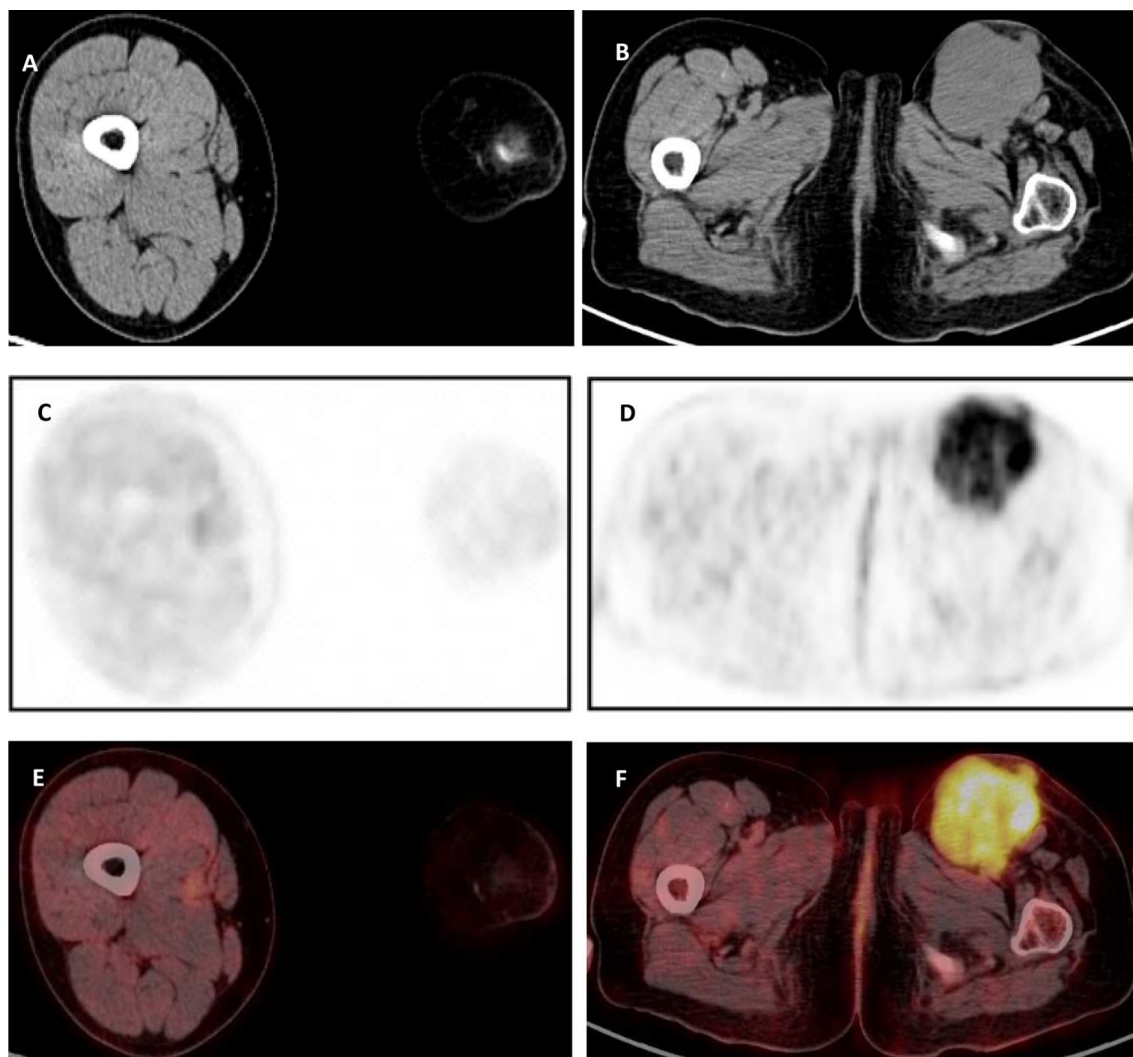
A 33 years old female patient with biopsy-proven left tibial Ewing sarcoma. She underwent an above-knee amputation and received chemo and radiotherapy that ended 1 year ago. The patient was referred for follow-up and detecting any viable tumors. A, B Axial CT, C, D Axial PET, and E, F Axial fused PET/CT images show no metabolically active local recurrent tumor at the operative bed, but a metabolically active FDG avid left femoral large lymph node is seen with SUVmax~6.48
